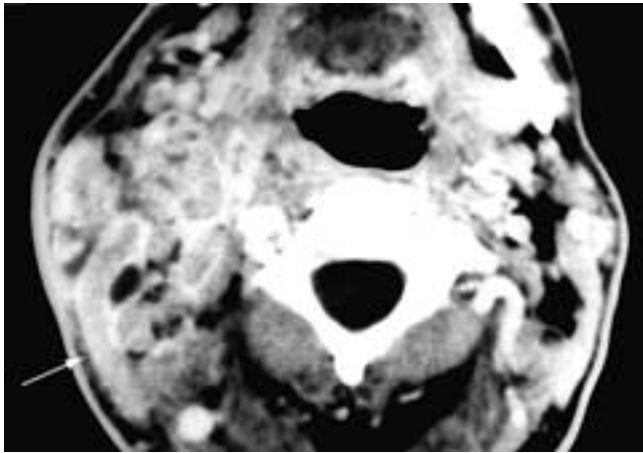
Axial contrast-enhanced CT scan shows multiple enhancing right level II nodes with some effacement of adjacent fat planes, involvement of the right sternocleidomastoid muscle (*arrow*), and overlying skin and subcutaneous fat planes. This patient was HIV positive and had tuberculosis. Possibly his HIV status accounted for the more aggressive imaging appearance of his tuberculosis.
